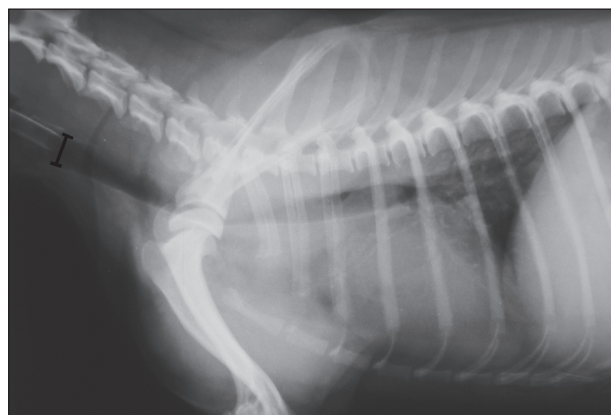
Lateral radiograph of the neck and the chest. The tracheal diameter just caudal to the radio opaque margin of the cricoid cartilage (consistent with first tracheal ring) was measured to select an adequate stent diameter.
